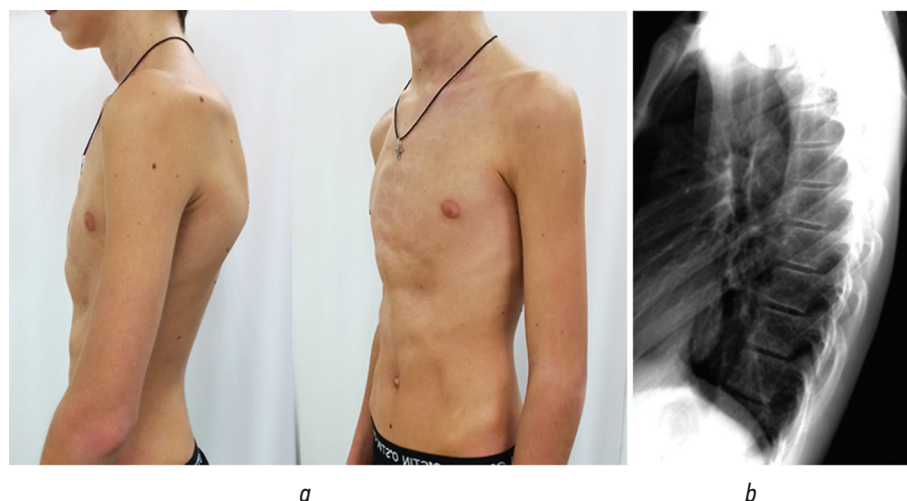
Appearance (a) and radiographs (b) of a 14-year-old child with pectus carinatum, back pain, neck hyperlordosis, and rounded shoulders. No pathological findings were noted on the lateral radiographs
